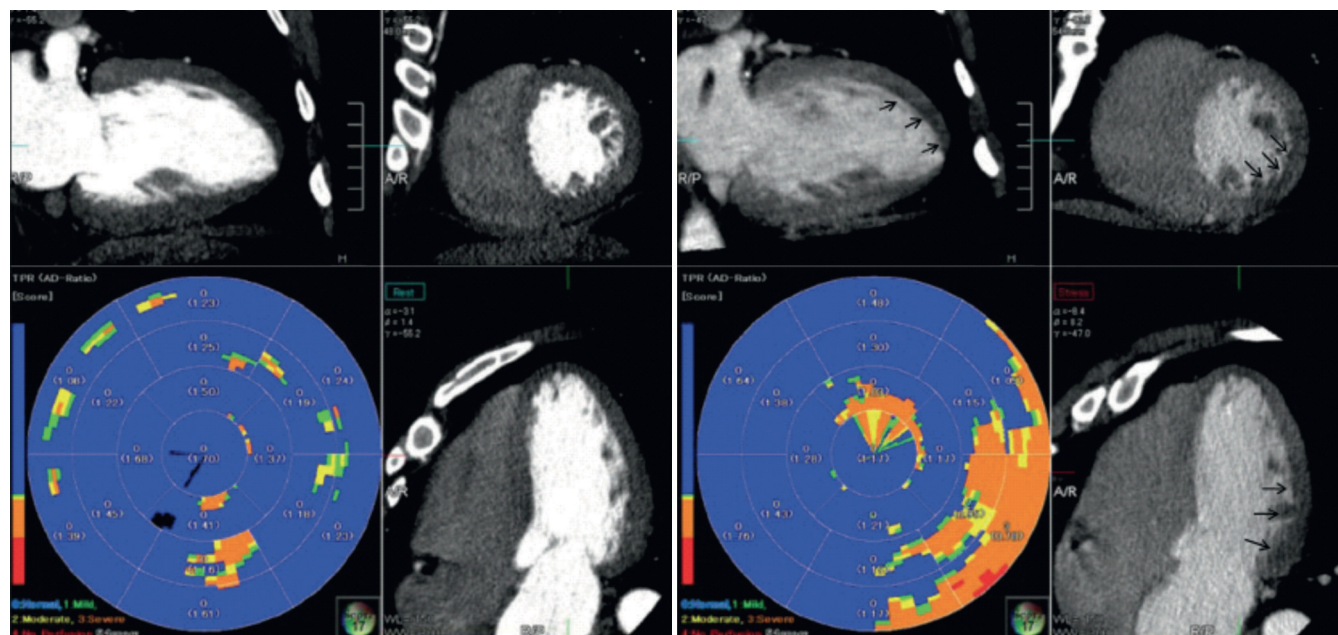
Stress CT myocardial perfusion imaging using adenosine. CT perfusion images including polar maps at rest (left) and during stress (right) disclose a reversible posterolateral perfusion defect (arrows) on the stress images. (From George RT, Arbab-Zadeh A, Miller JM, et al: Computed tomography myocardial perfusion imaging with 320-row detector computed tomography accurately detects myocardial ischemia in patients with obstructive coronary artery disease. *Circ Cardiovasc Imaging* 5:333, 2012.)
